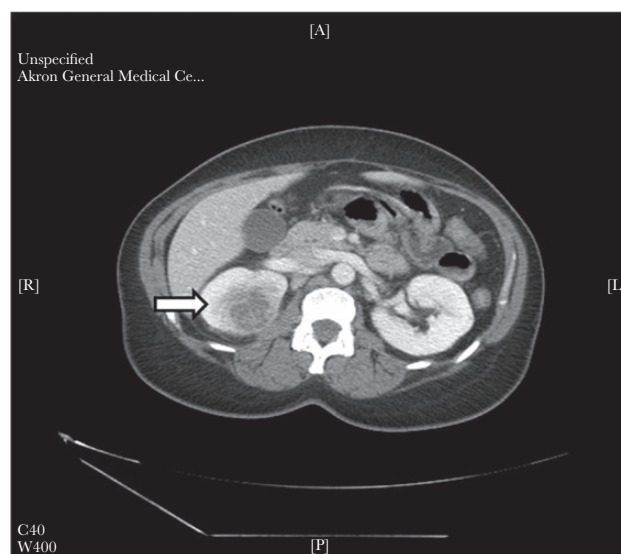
Initial computed tomography scan showing right renal abscess.
